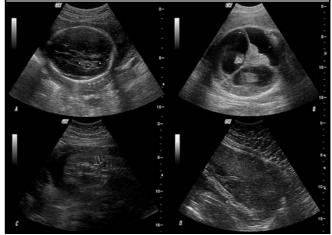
Ultrasonographic Finding of Dandy-Walker Syndrome, Choroid Plexus Cyst, Hemivertebra (A Multiple Choroid Plexus Cysts;B- Dandy-Walker Syndrome- ventriculomegaly and hypoplasia of cerebellar vermis; C Hemivertebra at T12-L1 region).
